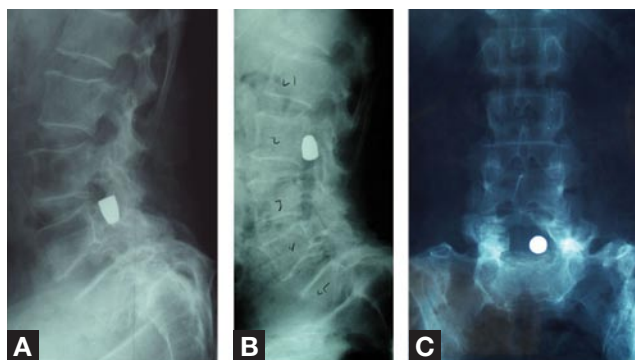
(A) Lateral x-ray of lumbosacral spine shows bullet lodged in spinal canal at L4. Note vertical orientation of missile and previous decompression and fusion at L4–S1 for isthmic spondylolysis. (B) Lateral x-ray myelogram shows even farther cephalad migration of bullet to L2. (C) Anteroposterior x-ray of lumbosacral spine. Note 90° change in bullet orientation from lateral x-ray. Bullet is now oriented horizontally, which confirms its migration.
